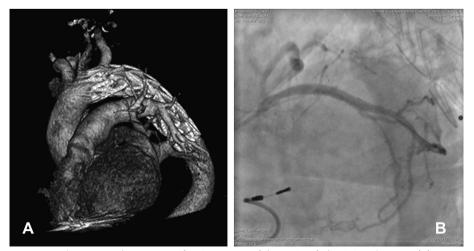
(A) One-year computed tomography scan confirming successful repair of the injured aorta; (B) coronary angiography after percutaneous coronary intervention.
